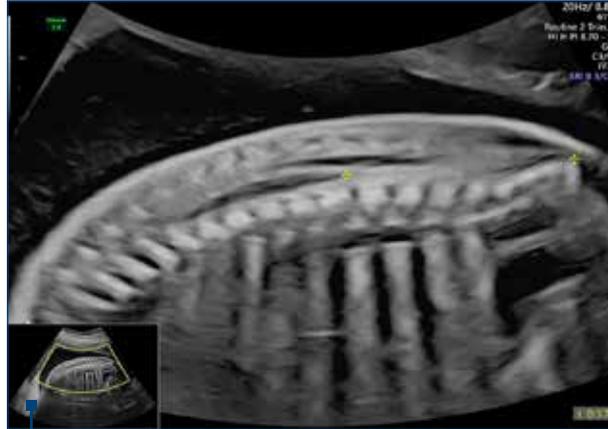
Two-dimensional ultrasound measurement of the conus medullaris. The identification in the midsagittal plane of the triangular conus medullaris (personal collection of dr. R. Bohilțea)
